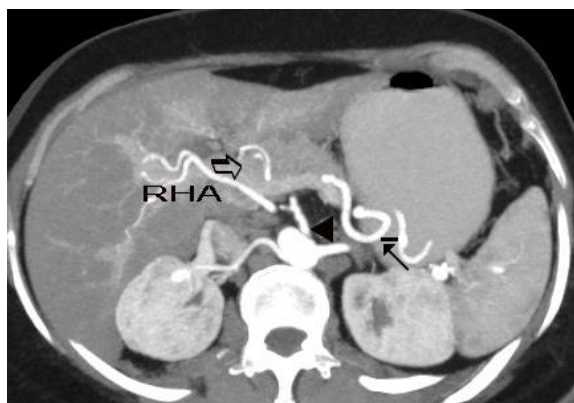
CT: replaced RHA from celiac trunk with dorsolateral position within porta hepatis; open arrow – PV, arrow – splenic artery, arrowhead – celiac trunk
